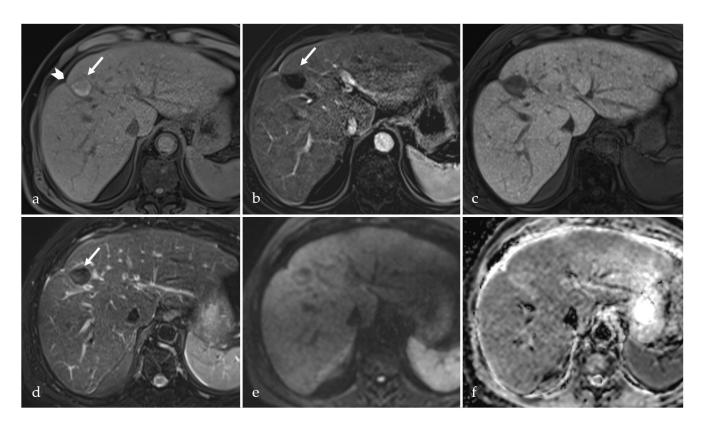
MRI examination with hepatospecific intravenous contrast of a patient with HCC in liver segment VIII, 5 months after RFA. Axial plane images: (a)—T1 weighted image with fat suppresion; (b)—subtraction image (obtained by subtracting a T1 fat saturated image without contrast enhancement from a T1 fat saturated image with contrast enhancement in the arterial phase; (c)—T1 WI with fat saturation in the hepatobiliary phase (obtained 20 min after contrast injection); (d)—T2 weighted image with fat saturation; (e)—diffusion weighted image; (f)—apparent diffusion coefficent map). There is an area of coagulative necrosis hyperintense on T1 fat-saturated images (arrow, (a,b)), hypointense on T2 fat sat (d), without restricted diffusion on DWI/ADC (e,f), non-enhancing in the arterial phase ((b), subtraction) or hepatobiliary phase (c). To better depict contrast enhancement in high-intensity T1 fat-saturated lesions, subtraction is a necessary tool. Also, there is capsular retraction on the needle path (chevron in (a)).
